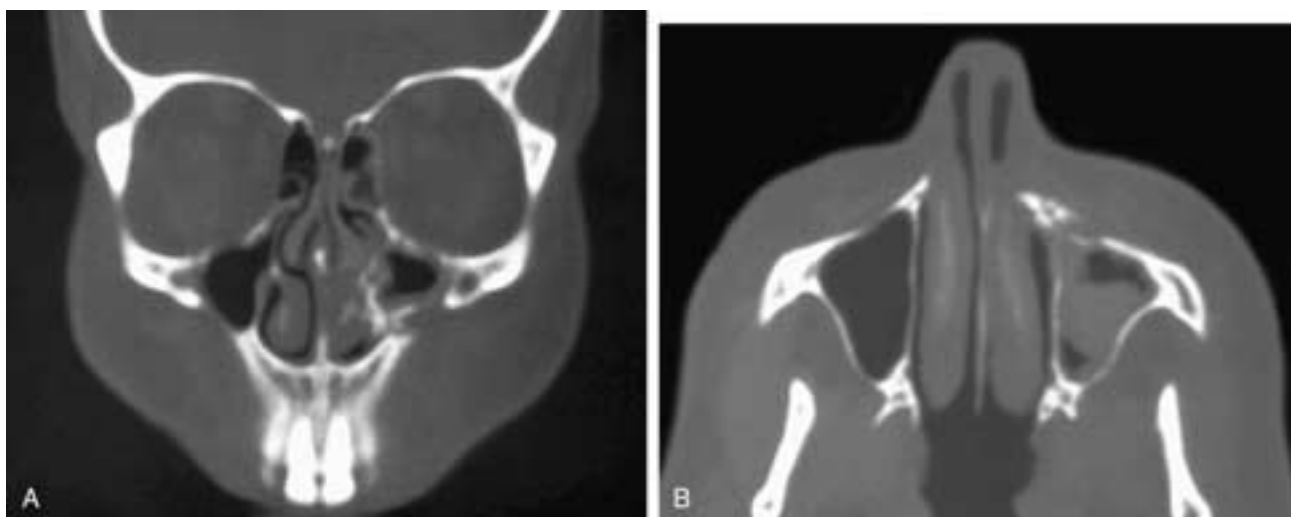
Coronal (A) and axial (B) CT scans show comminuted fractures involving the left anteromedial maxilla.
